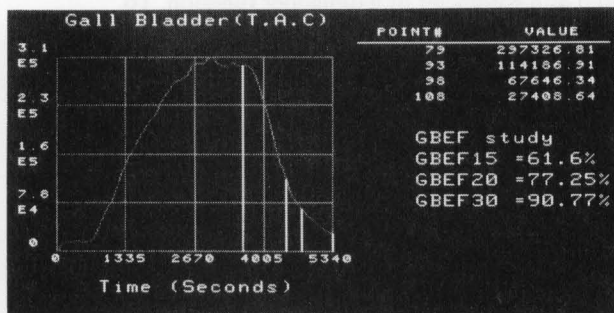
The time activity curve of the gallbladder of a volunteer using ^{99m}Tc -PMT hepatobiliary scintigraphy reduced clearly after cerulein injection at 60 min. It was calculated that GBEF was 91%.
